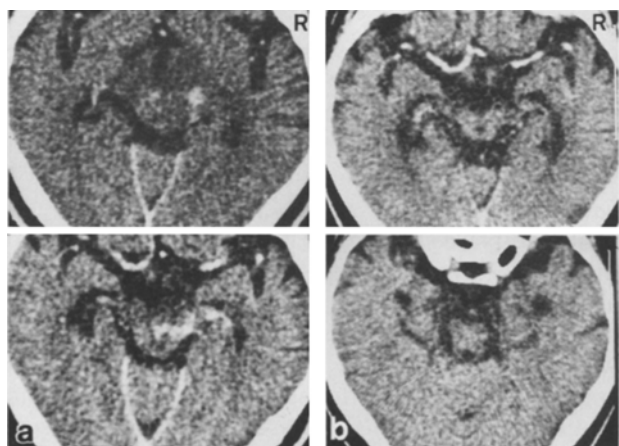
Enhanced CT scans of case 2. The left row (a) shows enhanced CT 5 days after onset of clinical symptoms. The right row (b) shows enhanced CT about 4 months after onset of clinical symptoms. a A low density area with irregular marginal enhanced effect is noted in the upper pons, midbrain and thalamus. Swelling of low density area is noted in the midbrain and thalamus and third ventricle is compressed by the right side thalamus. Involved structures are cerebral peduncle, midbrain tectum, periaqueductal gray matter, and hypothalamus. b Small low density areas are seen in the midbrain cerebral peduncle. There was a marked atrophy of the brain stem from the upper pons to midbrain
